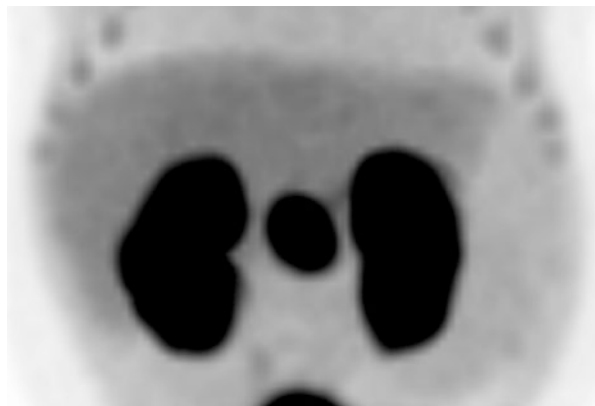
A 5-month-old with heterozygous recessive *ABCC8* mutation with focal lesion. Axial fused PET/CT image shows an exophytic lesion (arrow) arising from posterior aspect of the pancreatic body. A 5% pancreatectomy was performed and resulted in cure
